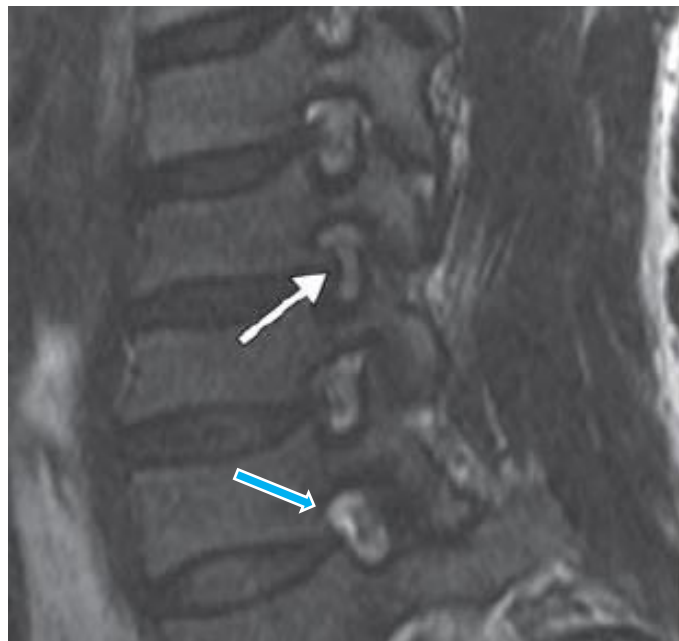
Oblique sagittal T2 MRI
